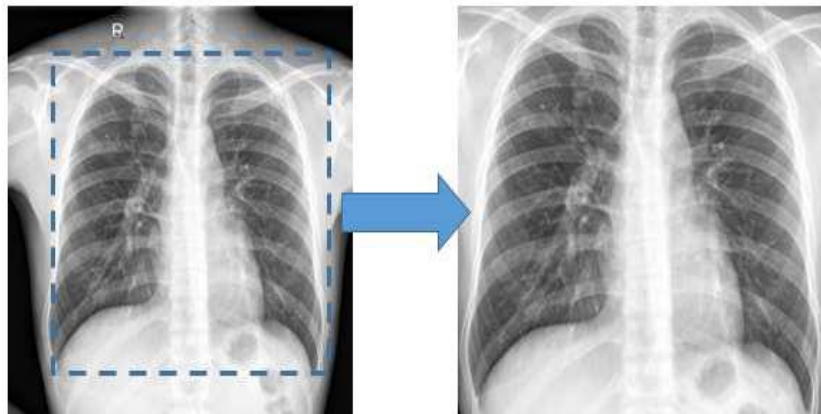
X-Ray Image, Adjusted and Cropped.
